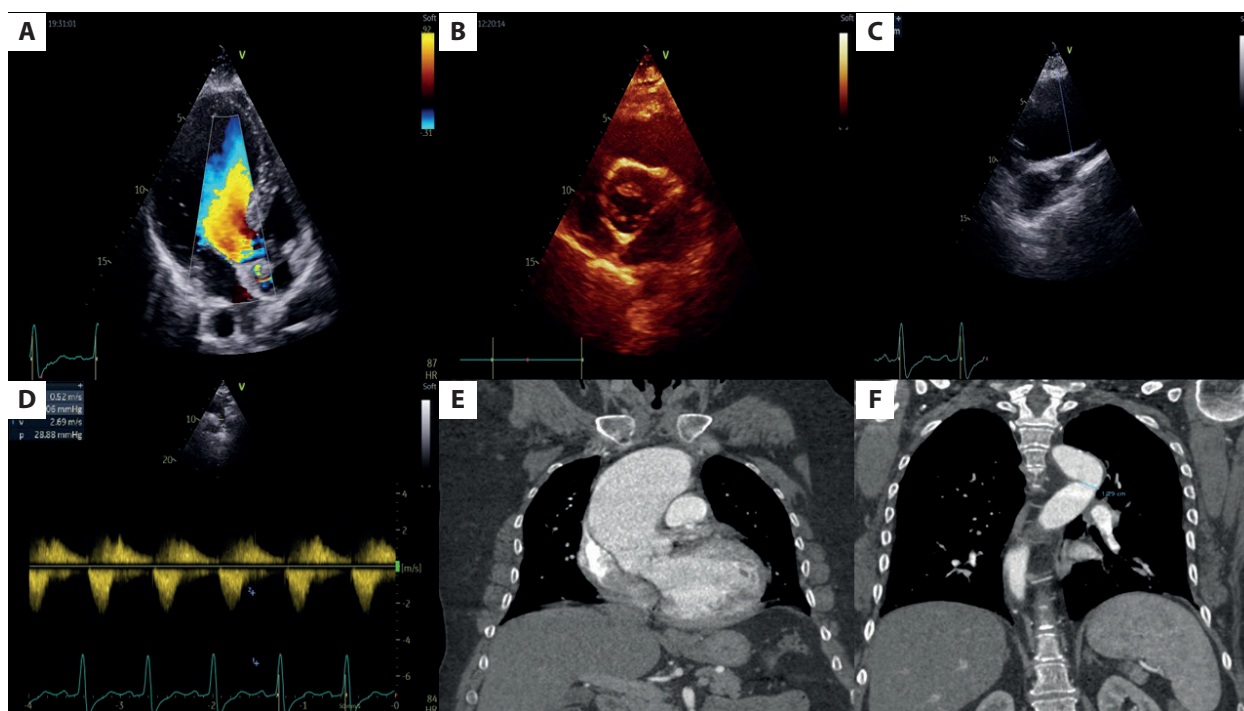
A. Severe aortic occlusion regurgitation. B. Bicuspid aortic valve. C. Ascending aortic aneurysm. D. Gradient at the site of narrowing of the descending aorta. E. Aortic aneurysm on computed tomography. F. Aortic isthmus stenosis on computed tomography
